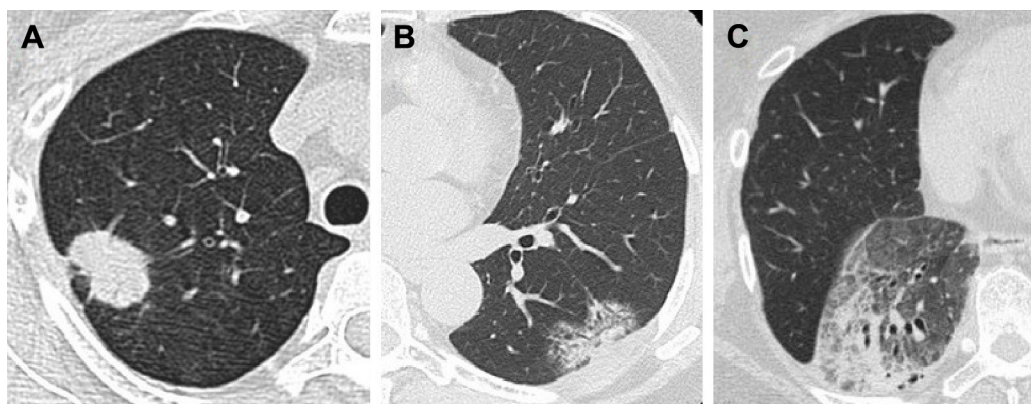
Computed tomography findings of lung invasive mucinous adenocarcinoma. Notes: (A) Solid type, (B) bubbling type, and (C) pneumonic type.
